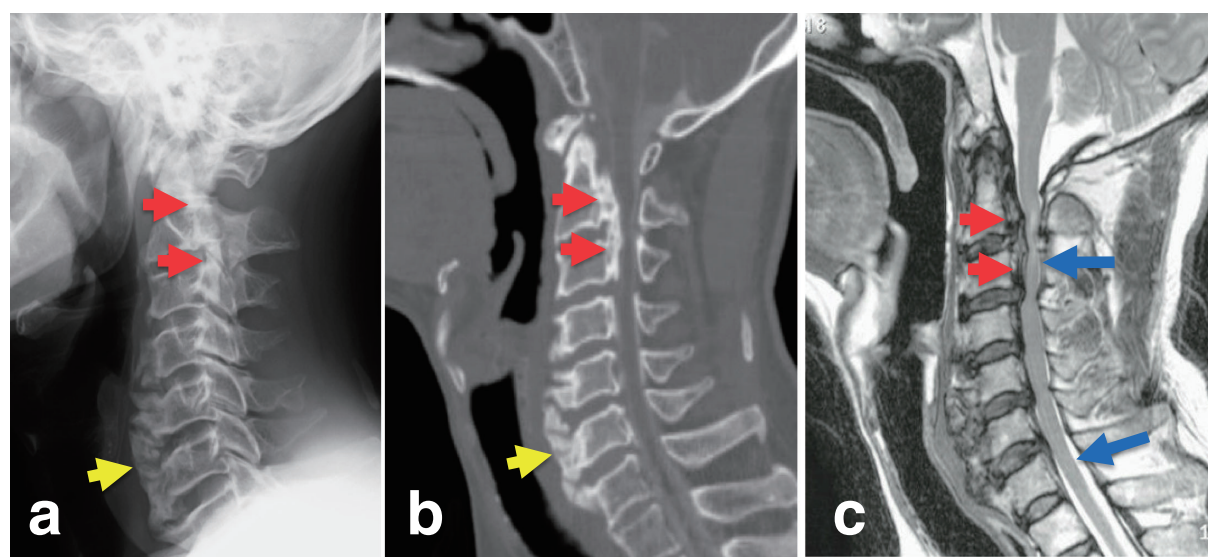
Ossification of the posterior longitudinal ligament of the spine (OPLL). The lateral cervical spine in a patient with OPLL by a) plain radiograph, b) reconstruction computed tomography (CT) and c) magnetic resonance imaging (MRI). Red arrow: OPLL, yellow arrow: OALL (ossification of the anterior longitudinal ligament), blue arrow: spinal cord. Spinal cord is compressed by OPLL and became thin.
